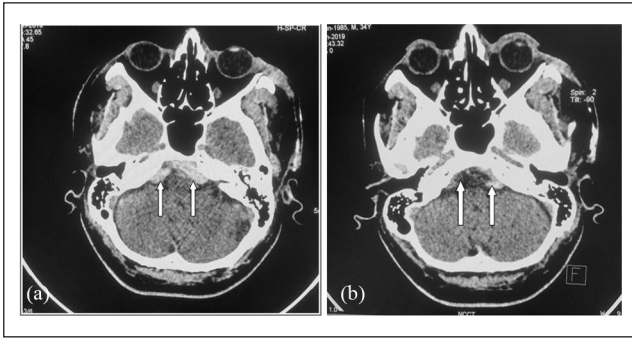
Axial CT scan of the head (a) with retroclival hematoma and (b) with resolution of the hematoma.
